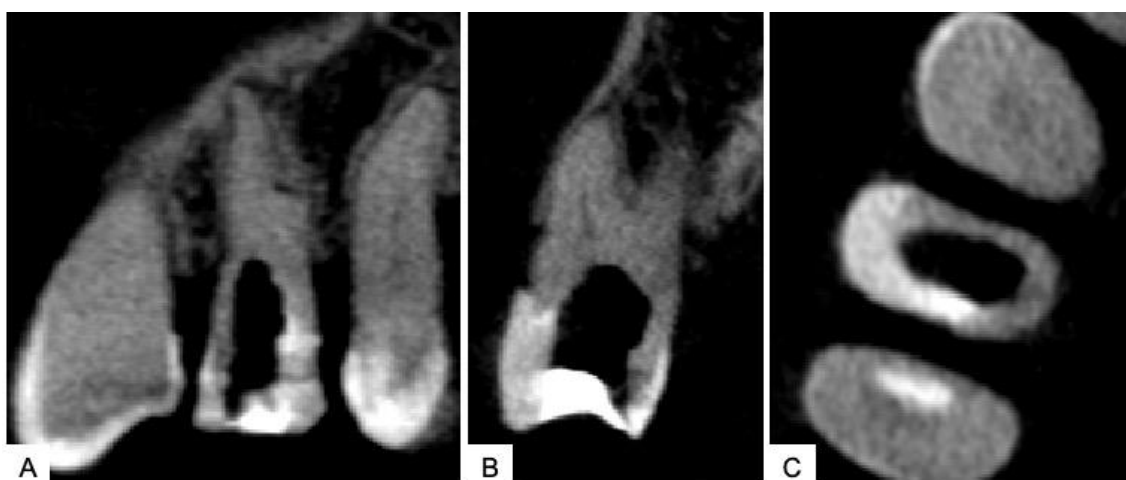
Preoperative cone-beam computed tomography (CBCT) images. A- Sagittal section; B- Coronal section; C- Axial section.
